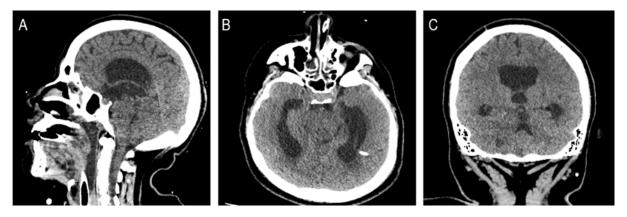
Brain Computed Tomography showing signs of acute hydrocephalus. Note in A and C, there are hypodense infratentorial lesions suggesting vesicular lesions.
